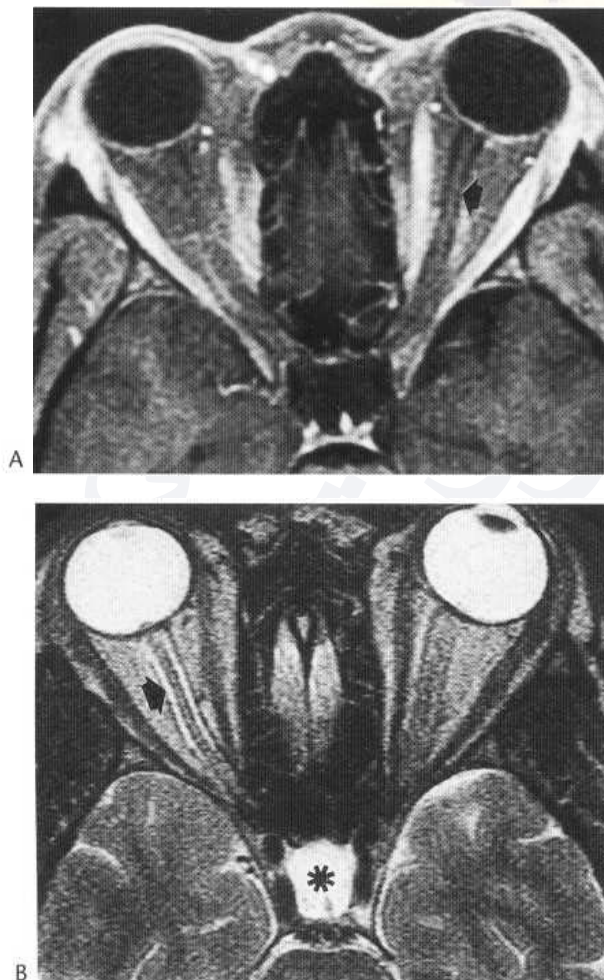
Pseudotumour cerebri. Enhanced, fat-saturated axial T₁-weighted (A) and T₂-weighted (B) MR images demonstrate dilated optic nerve sheath surrounding optic nerves (arrowheads). Papilloedema (seen on right in (B)) and fluid-filled empty sella (asterisk) are frequent accompanying findings.
